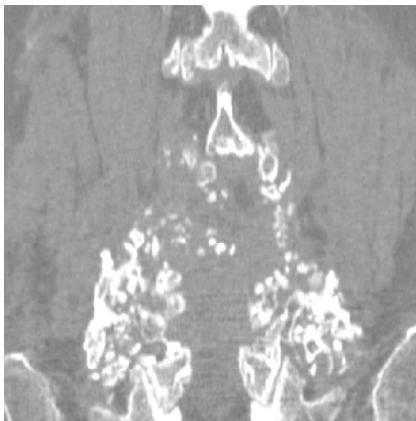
Coronal CT at 18 months post op
